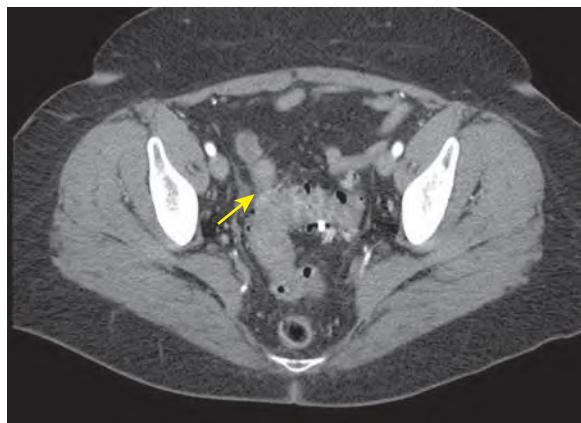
Sigmoid stricture. Computed tomography scan demonstrating a sigmoid stricture (arrow).
